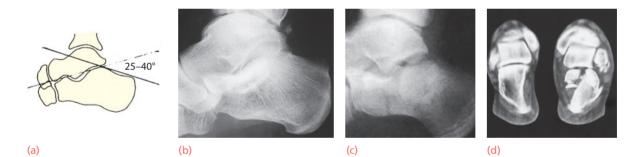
Fracture of the calcaneum – imaging (a,b) Measurement of Böhler's angle and the X-ray appearance in a normal foot. (c) Flattening of Böhler's angle in a fractured calcaneum. (d) The CT scan in this case shows how the articular fragments have been split apart.
